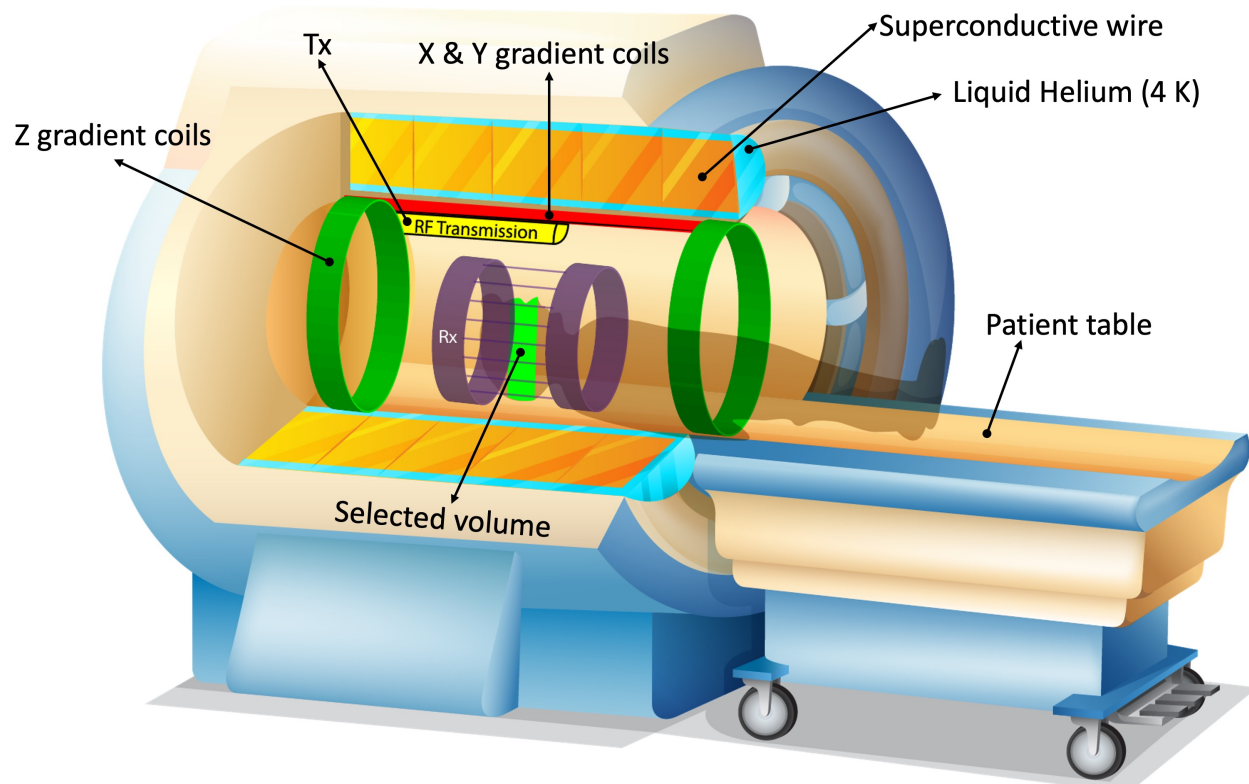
Hardware components of a modern MRI scanner using a superconductive magnet. Z-axis gradients (green rings) spatially vary the magnetic field, such that only the spins at a limited region (light green area in the patient's head) precess at the Larmor frequency ( $\gamma B_0$ ).
